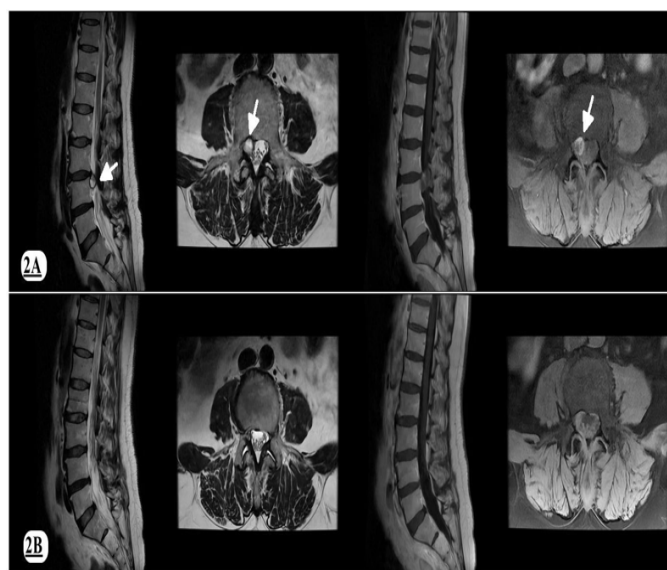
Lumbar MR images of a 57-year-old man scanned at a follow-up visit two months later showed the same shape and the location of the soft disc fragment with dense edema. MR images with gadolinium revealed that this extruded disc fragment showed high contrast enhancement (indicated with a white arrow) (2A). T2-weighted MR and MR images with gadolinium checked five months later revealed that the disc fragment in the patient had completely disappeared, and the right root was relieved (2B).
